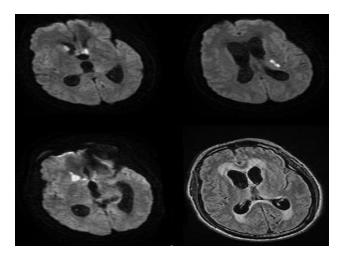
MRI Brain showing foci of diffusion restriction in the left periventricular region and basal ganglia and T2WI/FLAIR hyperintense signals in the periventricular region, basal ganglia and deep white matter
